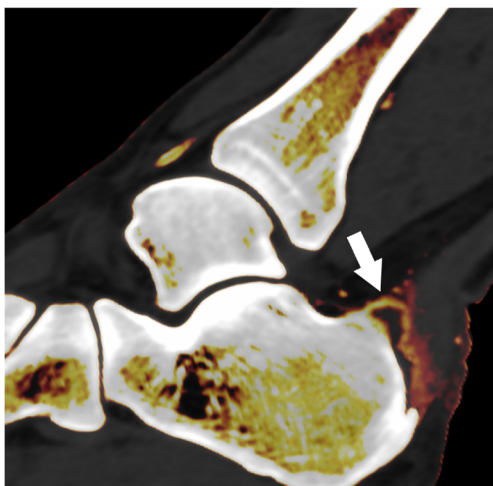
Achilles tendon enthesitis. Dual-energy computed tomography (DECT) iodine map of a 38-year-old patient with psoriatic arthritis (PsA) shows abnormal enhancement along the Achilles tendon and adjacent synovium of the retrocalcaneal bursa (arrow). There is bone proliferation at the Achilles tendon enthesal site of the calcaneus
